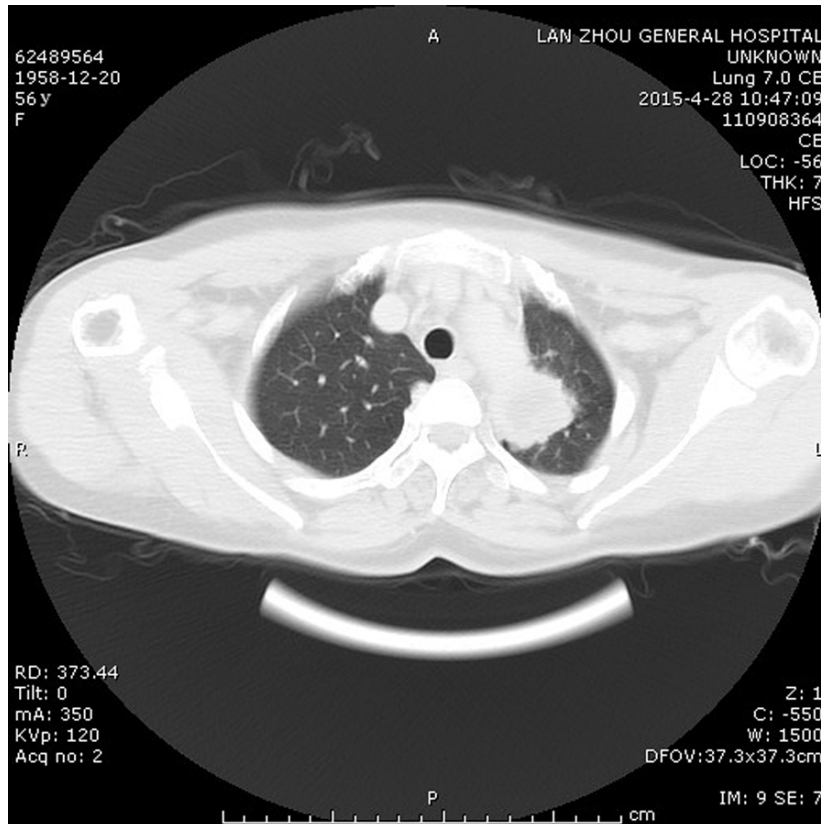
A lung computational tomography (CT) scan revealed a similarly round shadow was uneven density, within low-density areas, rough border, and showed filopodia-like changes among the surrounding lung tissue in the left upper lobe. It was next to mediastinum and unclear boundaries aortic arch, which size was approximately 3.3×3.4 cm, with multiple lymph nodes in the mediastinum appearing enlarged.
